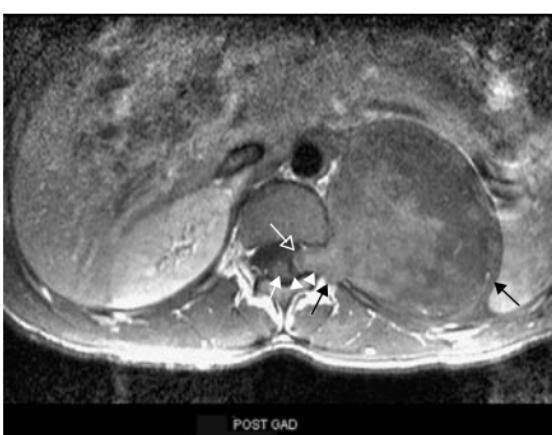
Large spinal neurofibroma. (a) Coronal T2W and (b) post-contrast enhanced axial MRI. Large well encapsulated left-sided extraspinal mass (black arrows) extending into the left lumbar intervertebral foramen (white arrowheads) causing distortion and displacement of the conus medullaris (closed white arrow). There is a small intradural component (open white arrow).
